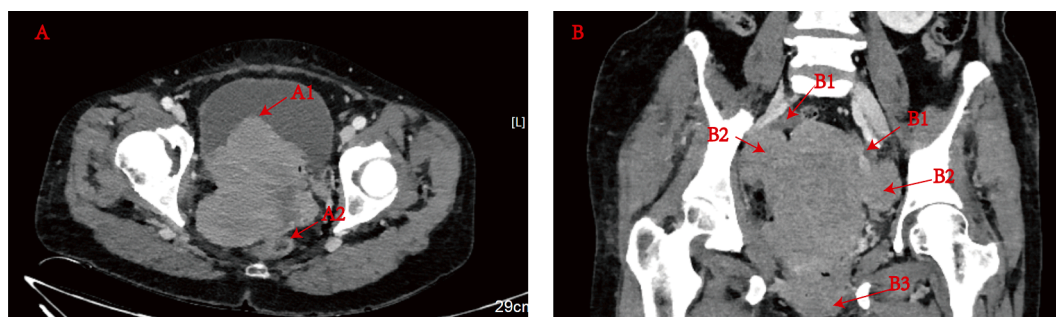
Pelvic imaging. A pelvic CT detected a thickening cervix with a bulky mass invading the posterior wall of the uterus and the vagina (B3). The cervical mass was poorly demarcated from the superior rectum (A2) and protruded into the bladder (A1). Enlarged lymph nodes were found bilaterally next to the iliac vessels (B1). The tumor invaded the bilateral lower ureter, resulting in dilatation of the upper ureter, with the right side being the most prominent (B1).
